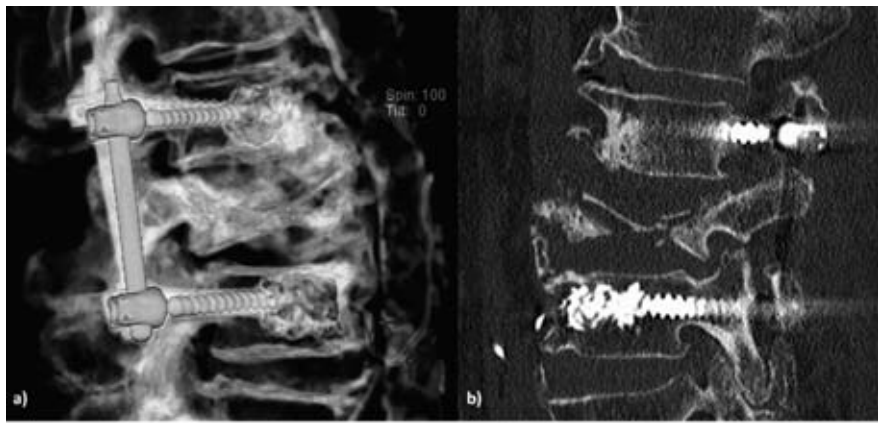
3D reconstruction (a) and sagittal computed tomography scan (b) showing bone cement migration (arrows) in the perivertebral lumbar vein extending into the inferior vena cava at the level of the 4th VB
